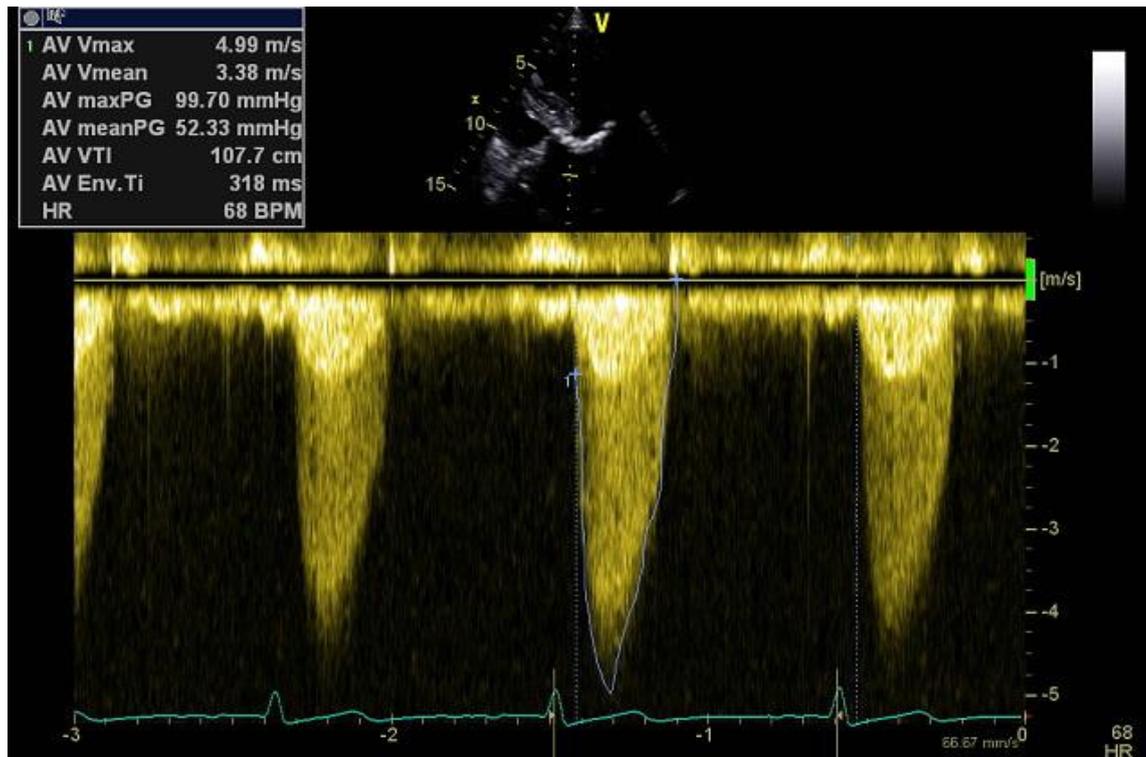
Continuous Wave Doppler through the aortic valve demonstrating severe aortic stenosis
